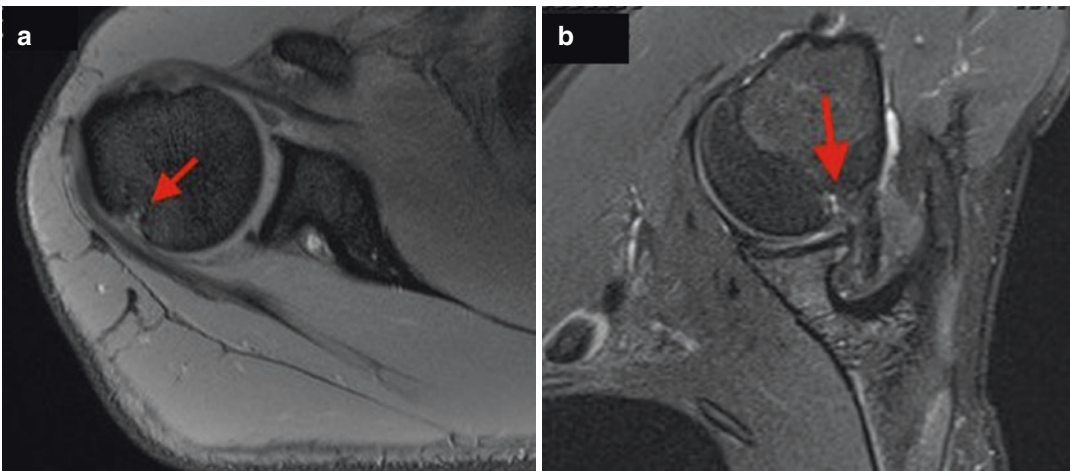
MRI of a right shoulder with internal impingement, pinching of the articular side of the rotator cuff and posterosuperior labrum between the greater tuberosity
